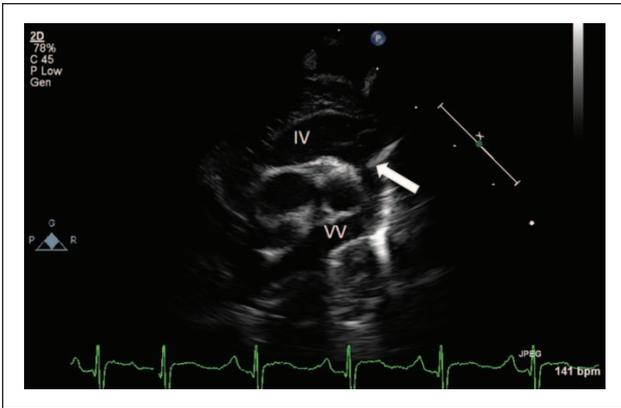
Supracardiac TAPVC to the innominate vein from a transthoracic suprasternal notch view: The vertical vein courses cephalad before entering the innominate vein just medial to the entry of the jugular veins. Minor 2D narrowing (arrow) is noted as the vessel enters the innominate vein. The innominate vein is severely dilated. The spectral Doppler from this patient is found in Figure 1D. Abbreviations: TAPVC, total anomalous pulmonary venous connection; IV, innominate vein; VV, vertical vein.
